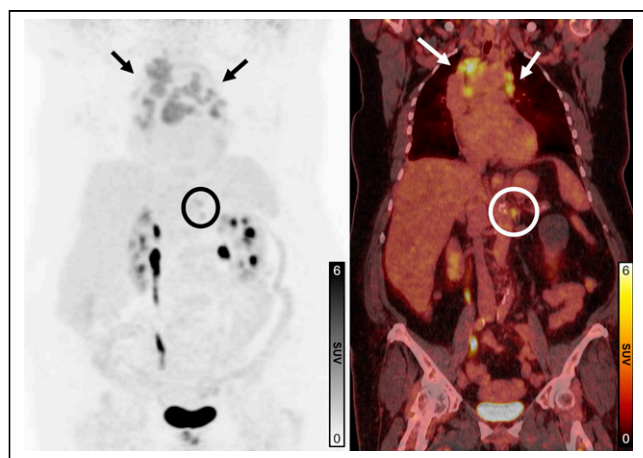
Scan 2 ^{18}F -FDG maximum-intensity projection (left) and ^{18}F -FDG PET/CT fused coronal (right) images. Persistent ^{18}F -FDG-avid bilateral mediastinal and hilar/perihilar adenopathy is visualized from known extracardiac sarcoidosis (arrows). Solitary ^{18}F -FDG-avid left upper abdominal node is suspicious for additional sarcoid involvement (circles).
